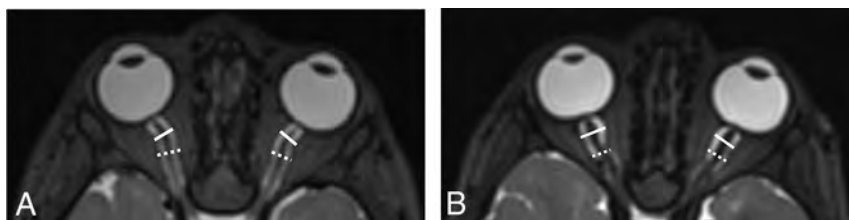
A, Axial T2-weighted MR image of the brain shows *white solid lines* indicating the retrobulbar ONSD and *white dashed lines* indicating the midpoint of the ONSD. This patient's OP was elevated at 31 cm H₂O, while the average ONSD was 5.8 mm at the retrobulbar area and 5.4 mm at the midpoint. B, Axial T2-weighted MR image of the brain shows *white solid lines* indicating the retrobulbar ONSD and *white dashed lines* indicating the midpoint ONSD. The courses of the optic nerves in this patient are more tortuous than those in the patient shown in A. This patient's OP was normal at 17 cm H₂O, while the average ONSD was 8.3 mm at the retrobulbar area and 6.5 mm at the midpoint.
